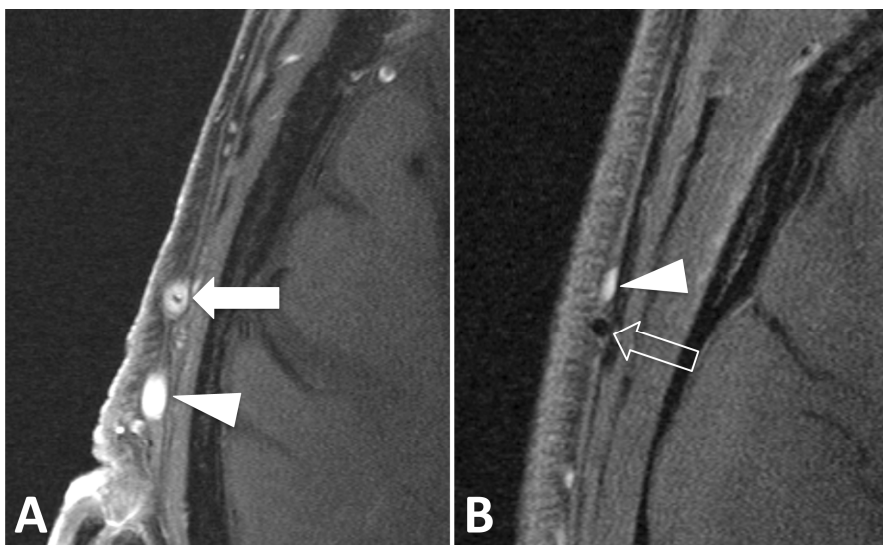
Post contrast MRI of the superficial temporal artery
